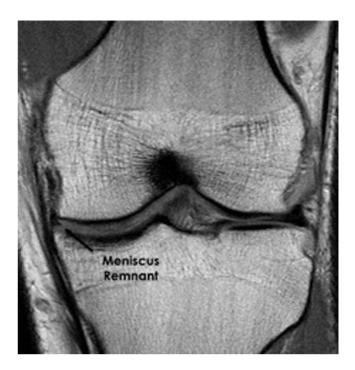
Left knee magnetic resonance imaging (T1) demonstrating a previously excised medial meniscus with extrusion of the remnant tissue (assigned 1 of 3) in this cut of the body of the meniscus.
